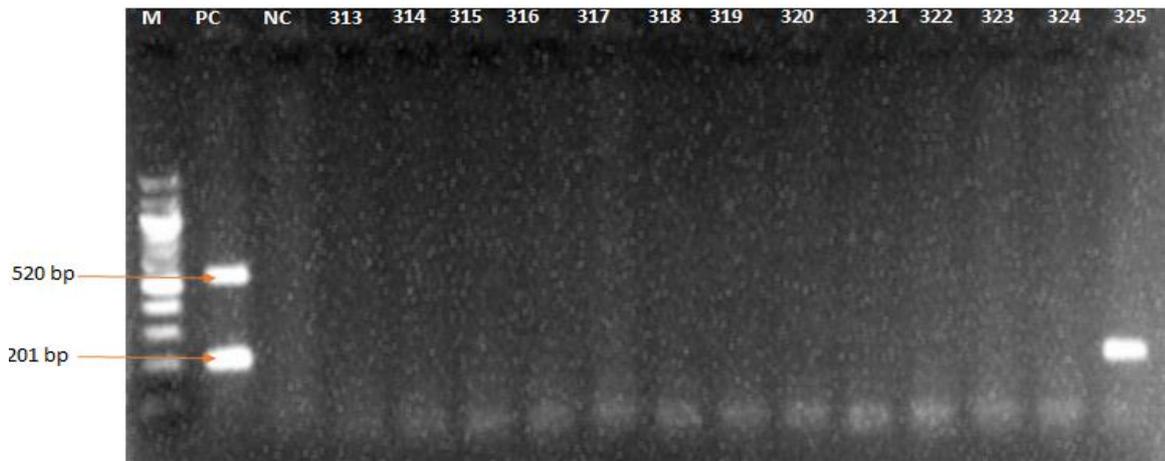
A representative gel picture of the multiplex run of CT DNA
